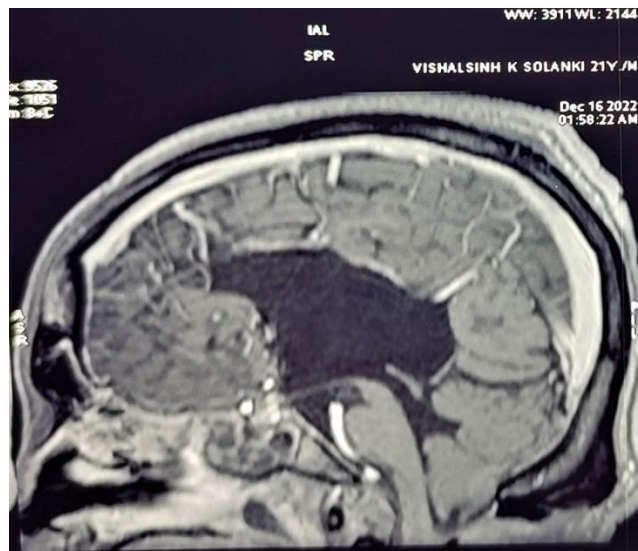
MRI Brain (T1W with contrast) sagittal section showing absent corpus callosum with high riding third ventricle
